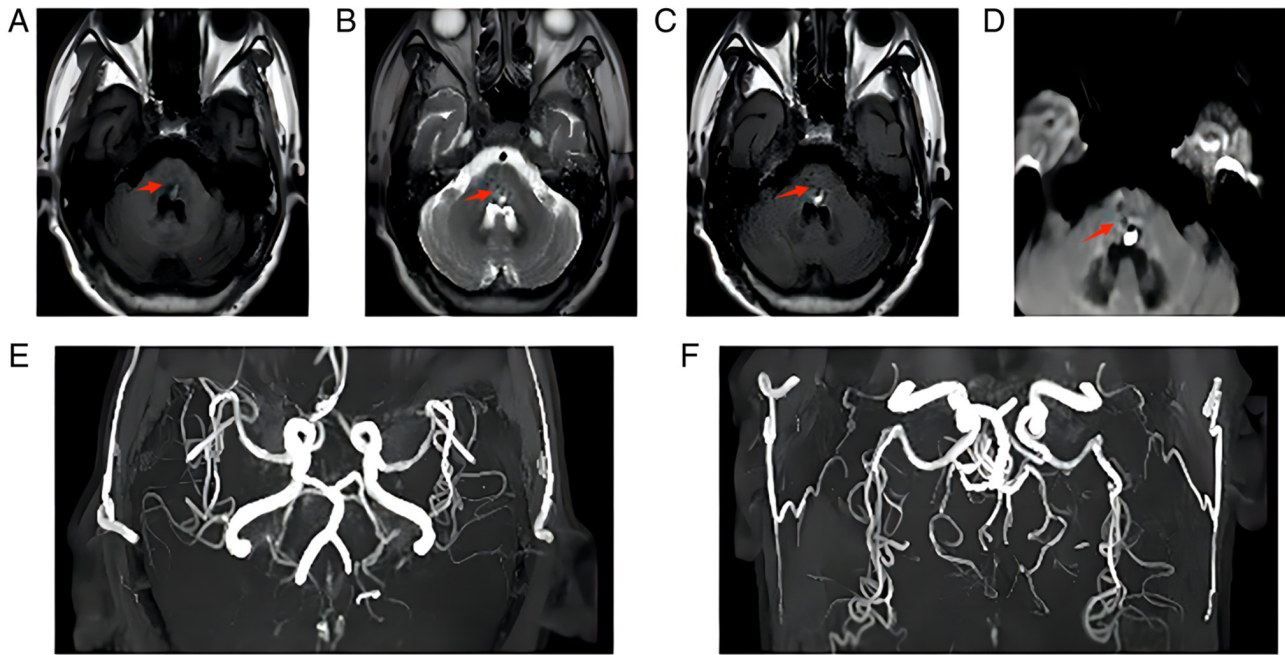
Cranial magnetic resonance imaging + magnetic resonance angiography on 31st May showed a piece of (A) short T1 and (B) long T2 dominant mixed signal shadow in the cerebral bridge, surrounded by low signal. (C) fluid attenuated inversion recovery and (D) diffusion-weighted imaging showed high signal locally, and cerebral bridge haematoma was considered. (E and F) The lumen of the M1 segment of the left middle cerebral artery was slightly narrowed, and the posterior cerebral artery was stiffened bilaterally, with uneven lumen thickness and slightly reduced branches, which indicated cerebral arteriosclerosis. The red arrow shows the haemorrhage site.
